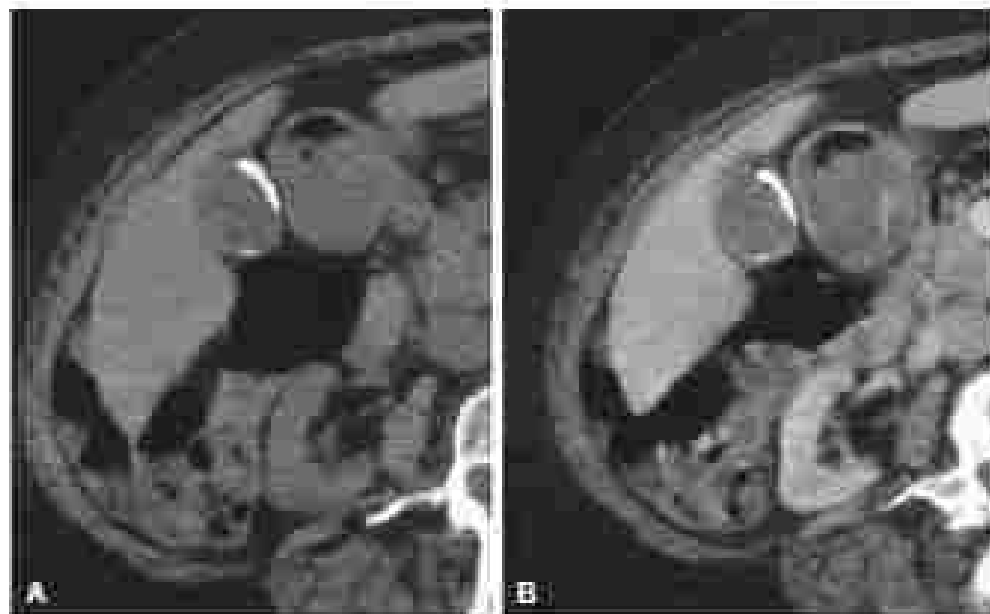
Axial visualization of gallbladder wall. (A) Noncontrast computed tomogram. (B) 100-ml-extended computed tomogram 400, 600 mm for comparison.
